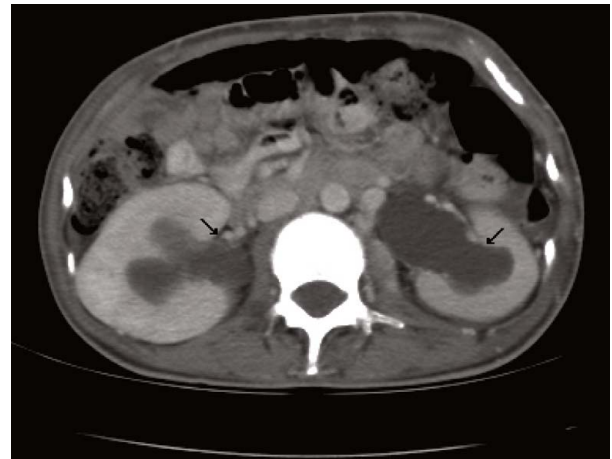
Computed tomography scan with contrast. The arrows indicate the hydroureter.
